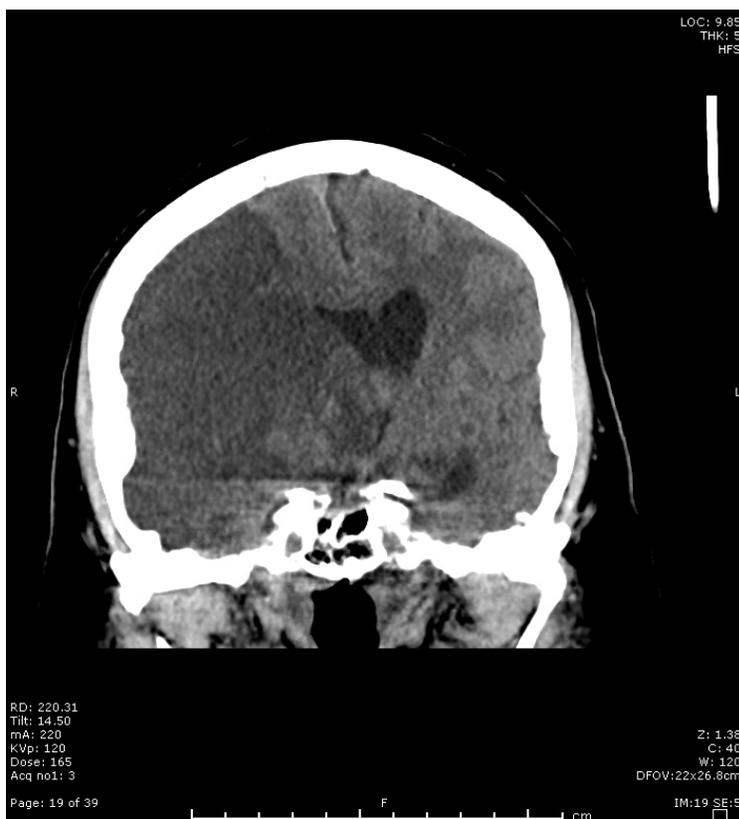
Coronal representation of ischemic stroke on noncontrast CT imaging
